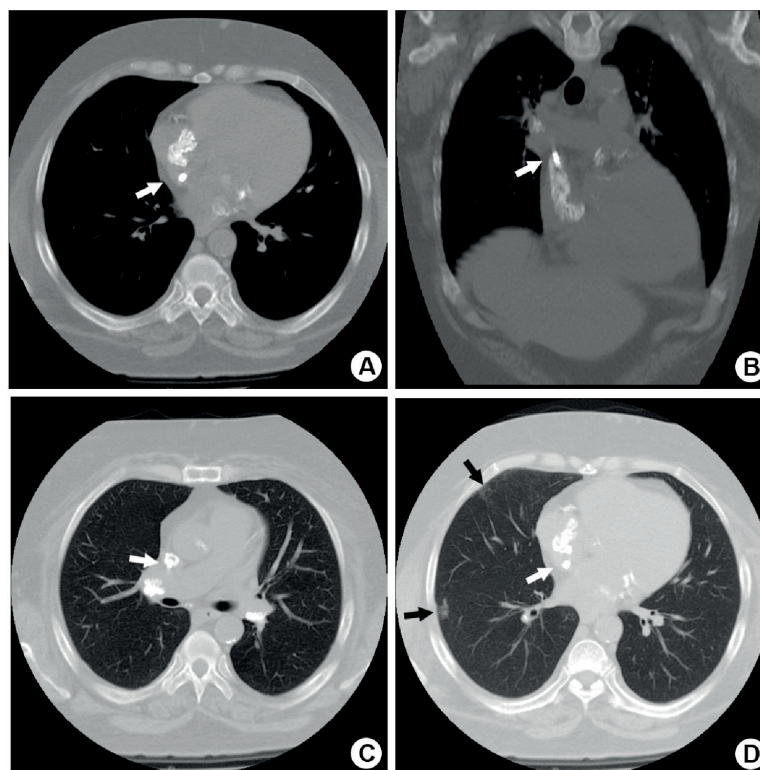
CT-scan of the chest. A and B show an image of calcium density, measuring about 31 x 22 x 19 mm in the right atrium (white arrow), attached to the hemodialysis catheter. C – calcified thrombus in the pulmonary artery branches (white arrow). D – pulmonary infarction in the periphery of the right lung (black arrow).
